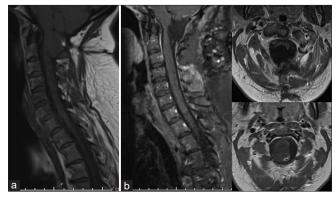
Preoperative sagittal cervical magnetic resonance imaging (MRI) T1-weighted sequence without contrast (a) and cervical MRI sagittal and two axial slices through the tumor T1-weighted sequence with contrast (b).
